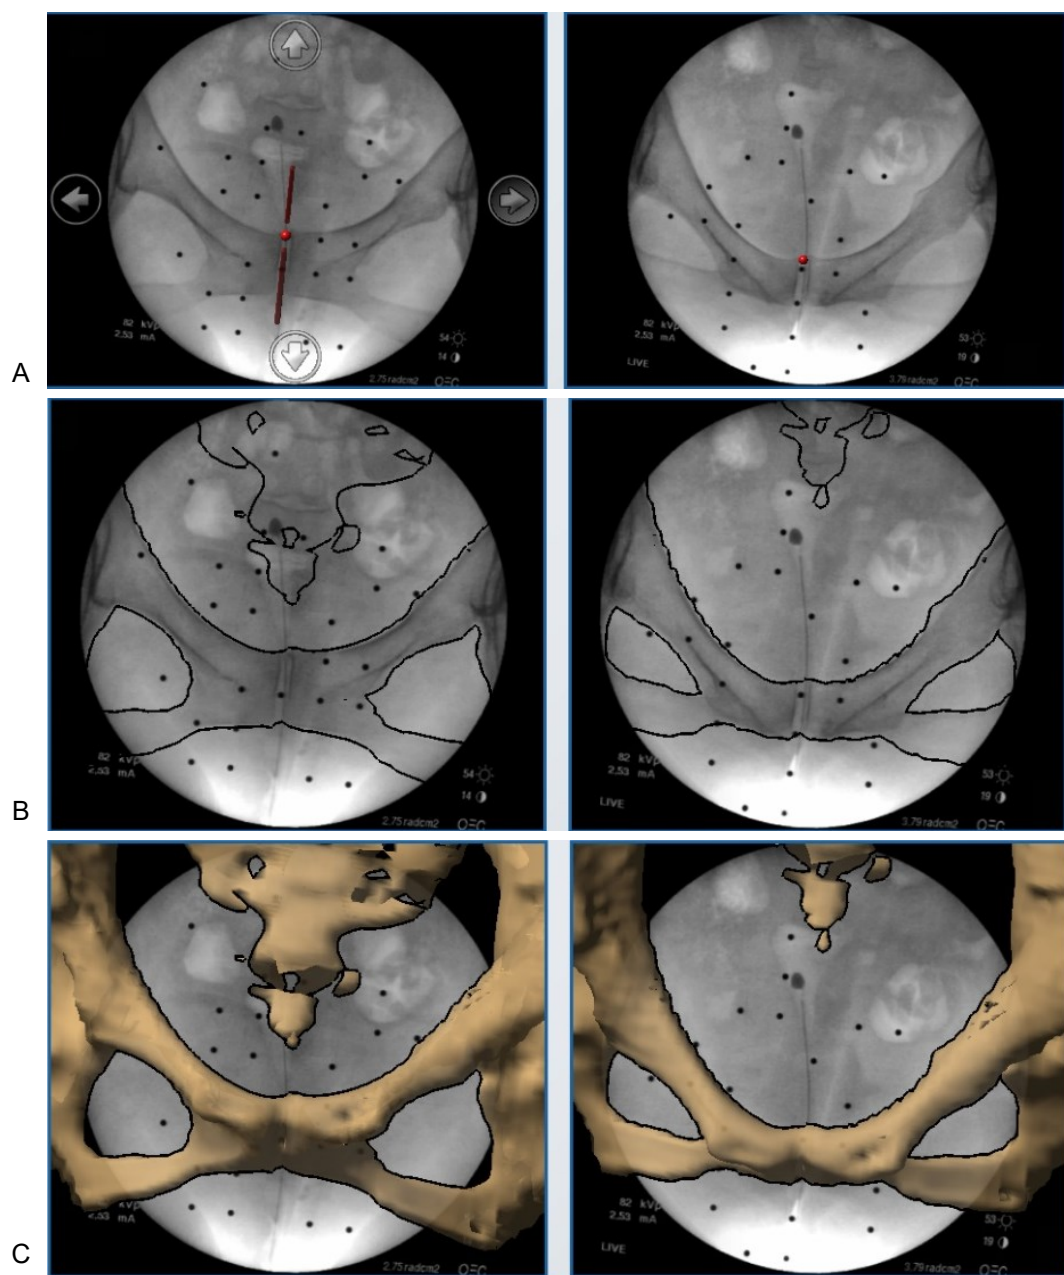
Intraoperative screenshot of CT-based 2D-3D matched navigation system. (A) Two fluoroscopic pelvic images taken from different angles of more than 20° . (B) (C) Fluoroscopic images were matched to three-dimensional pelvic images reconstructed from preoperative CT data.
